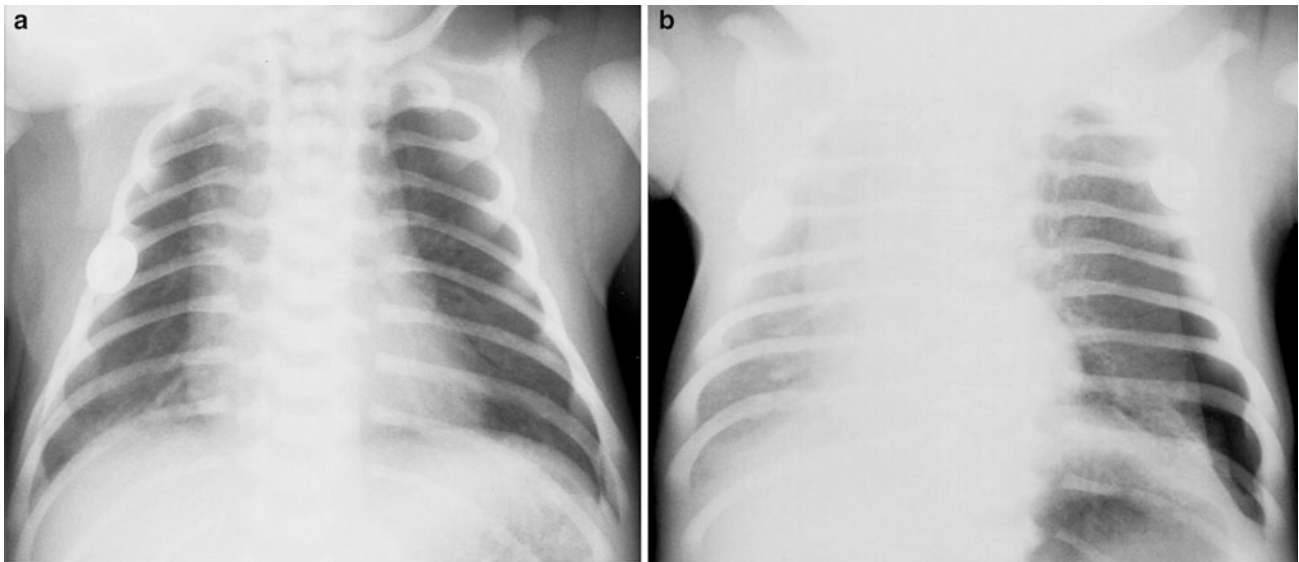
Frontal chest radiograph. (a) shows subtle left hemithorax hyperlucency and mediastinal shift, in a newborn. An expiratory view. (b) shows air in the pleural space and the “free lung edge” sign
